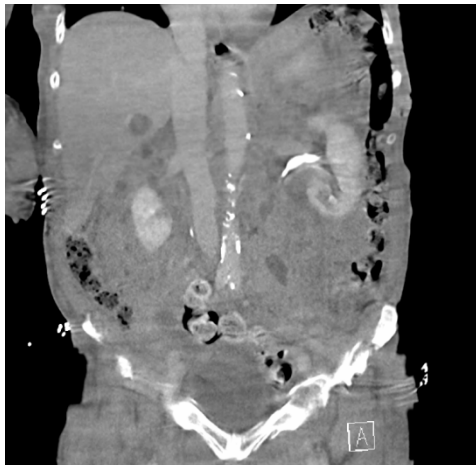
Coronal contrast enhanced CT Abdomen/Pelvis showing widespread metastatic disease
